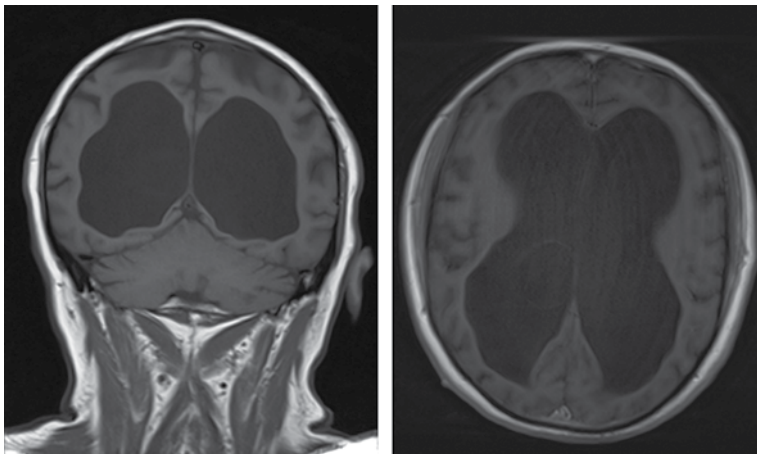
MRI brain scan demonstrating normal pressure hydrocephalus.
